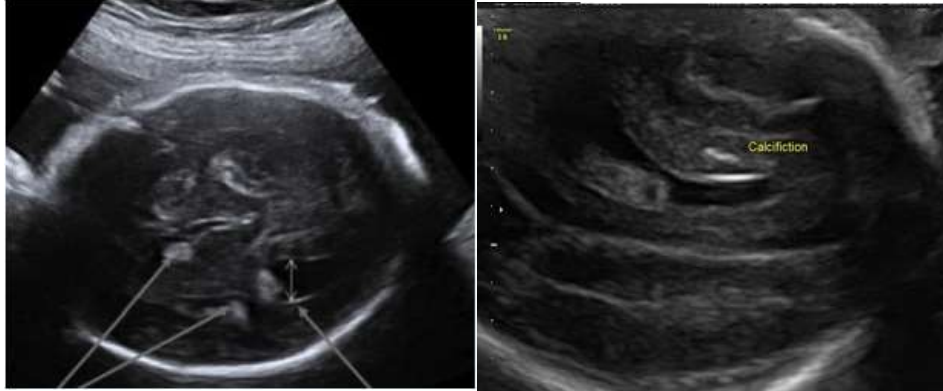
[11]: Fetal brain ultrasound at 28 weeks of gestation, transverse section.
